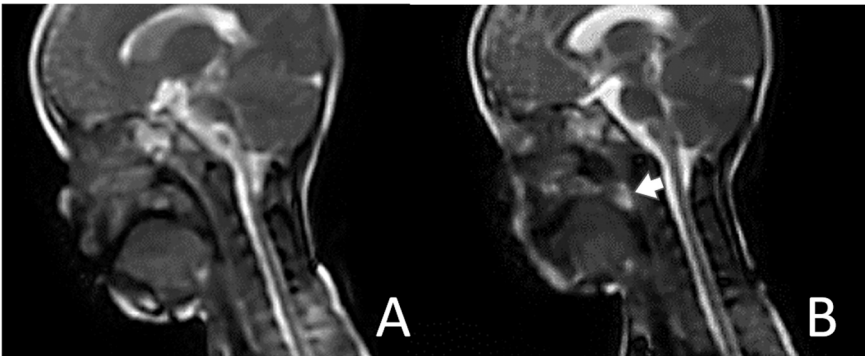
Representative MRI scans during speech before (A) and after (B) endoscopic soft palate augmentation in case 4. After endoscopic soft palate augmentation, the injected fat tissue appeared as a white lesion (arrow) in the soft palate on MRI, and the patient's soft palate could touch the velopharyngeal posterior wall more easily.
